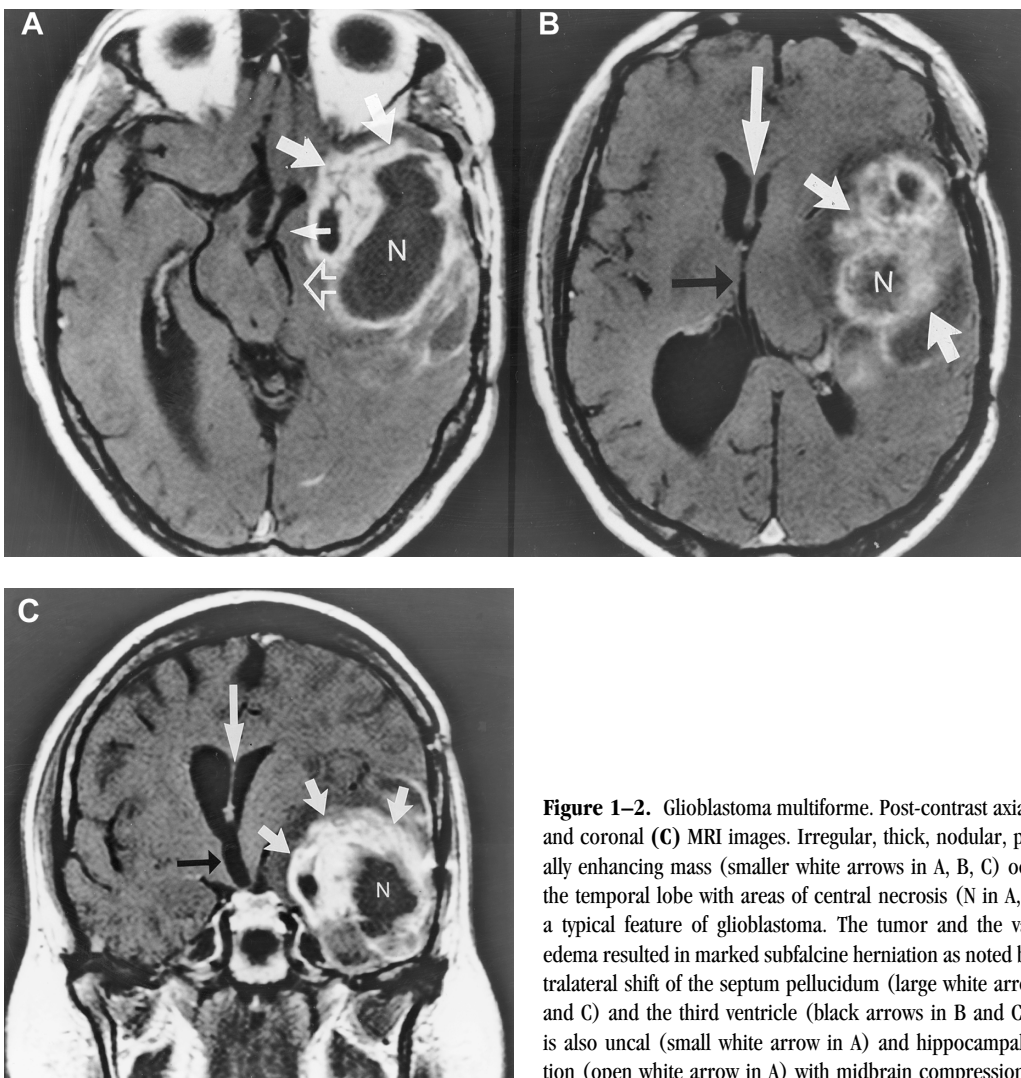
Glioblastoma multiforme. Post-contrast axial (A, B) and coronal (C) MRI images. Irregular, thick, nodular, peripherally enhancing mass (smaller white arrows in A, B, C) occupying the temporal lobe with areas of central necrosis (N in A, B, C) is a typical feature of glioblastoma. The tumor and the vasogenic edema resulted in marked subfalcine herniation as noted by a contralateral shift of the septum pellucidum (large white arrows in B and C) and the third ventricle (black arrows in B and C). There is also uncus (small white arrow in A) and hippocampal herniation (open white arrow in A) with midbrain compression.
